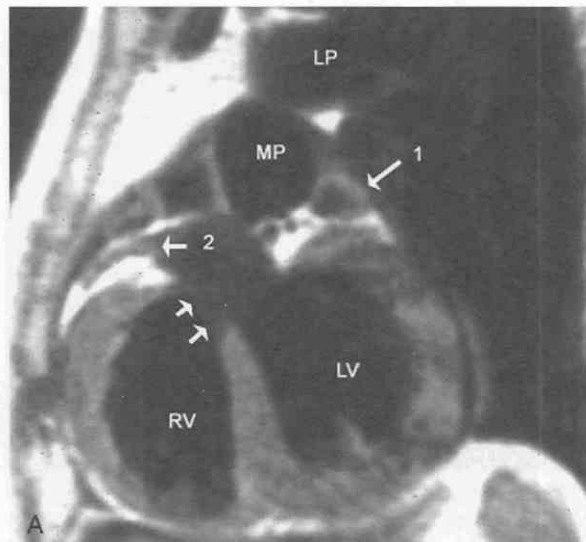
MR images obtained from a 53-year-old woman with tetralogy of Fallot. She had received palliative treatment 45 years earlier with a Blalock-Taussig shunt. A, Left anterior oblique sagittal spin-echo acquisition through the aortic root shows how the large subaortic ventricular septal defect (VSD) (paired arrows) affords communication between the hypertrophied right ventricle (RV) and the mildly dilated left ventricle (LV). The aortic root overrides the VSD. The origin of the right coronary artery (arrow 2) is seen. Arrow 1, left atrial appendage. B, Axial spin-echo acquisition obtained through the aortic valve. The anteriorly malaligned crista supraventricularis (arrows) causes posterior impingement on the hypertrophied right ventricular outflow (RVO) and leaves the VSD behind. Notice the right-sided descending aorta (Ao) in this patient with a mirror-image right aortic arch. LA, left atrium; LV, left ventricle; RA, right atrium.
